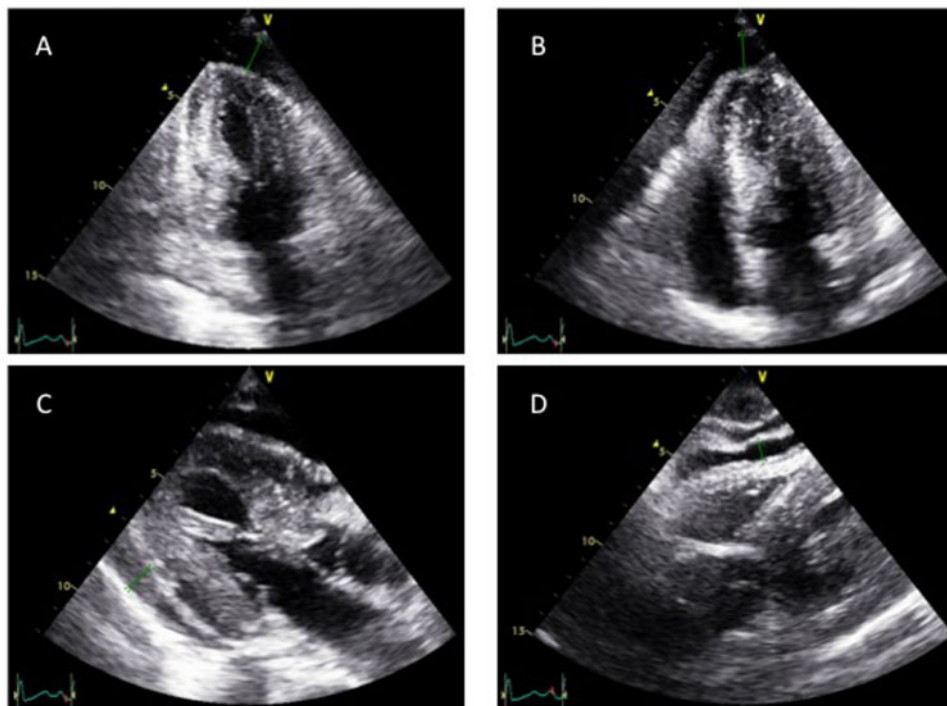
Different views on bedside trans-thoracic echocardiogram showing pericardial effusion: (A) apical two-chamber view, (B) apical four-chamber view, (C) parasternal long axis, and (D) subcostal view. Green arrow denotes the pericardial effusion of ~2 cm on the different views.
